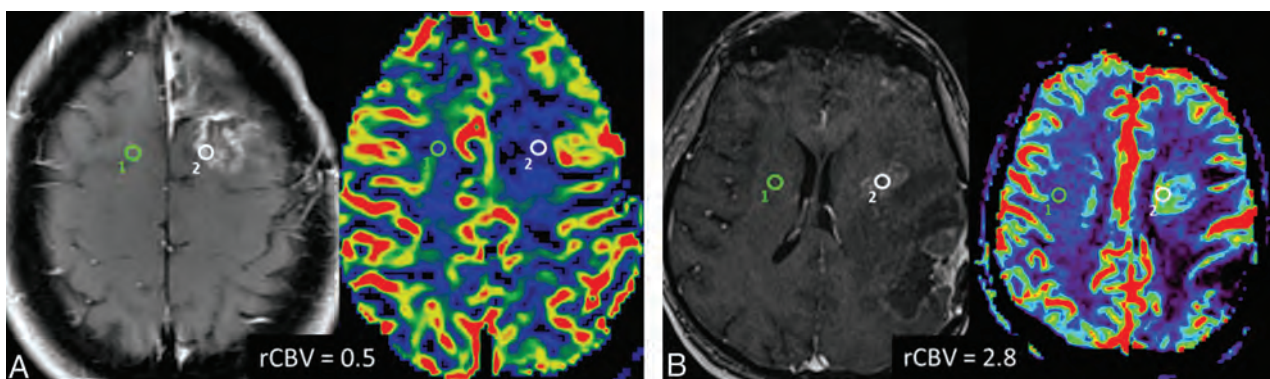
DSC perfusion in pseudoprogression and progressive disease. A, Axial contrast-enhanced T1-weighted and the corresponding rCBV map images show an enhancing lesion that developed after radiation therapy and temozolomide in a 46-year-old patient with multicentric GBM. The DSC perfusion of the enhancing lesion in the surgical bed (white ROI) shows decreased rCBV (0.5) in comparison with normal contralateral white matter (green ROI), which is consistent with predominance of radiation injury within the lesion (pseudoprogression). B, Axial contrast-enhanced T1-weighted and corresponding rCBV map images in a 60-year-old patient with a previously resected GBM show an enhancing lesion (white ROI) close to the margin of the radiation field. The DSC perfusion of the enhancing lesion in the surgical bed shows increased rCBV (2.8) in comparison with normal contralateral white matter (green ROI), indicating predominance of malignant cells within the lesion (progressive disease).
